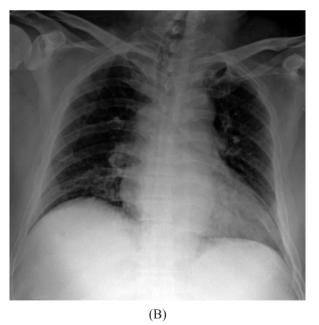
(A) Abdominal CT reveals a recurrent hepatocellular carcinoma with the largest diameter of 2.0 cm in the liver tip of segment VI. (B) The initial chest roentgenography shows no particular abnormality.
